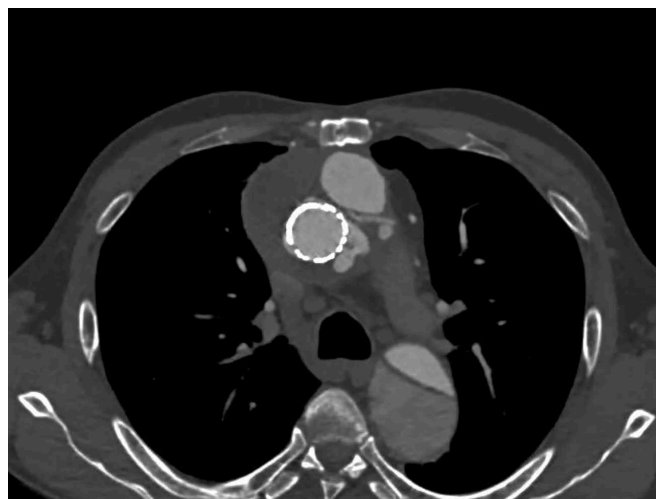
A computed tomography (angio-CT) scan performed 5 days after the surgery, showed that the stent was well positioned without any complication.
